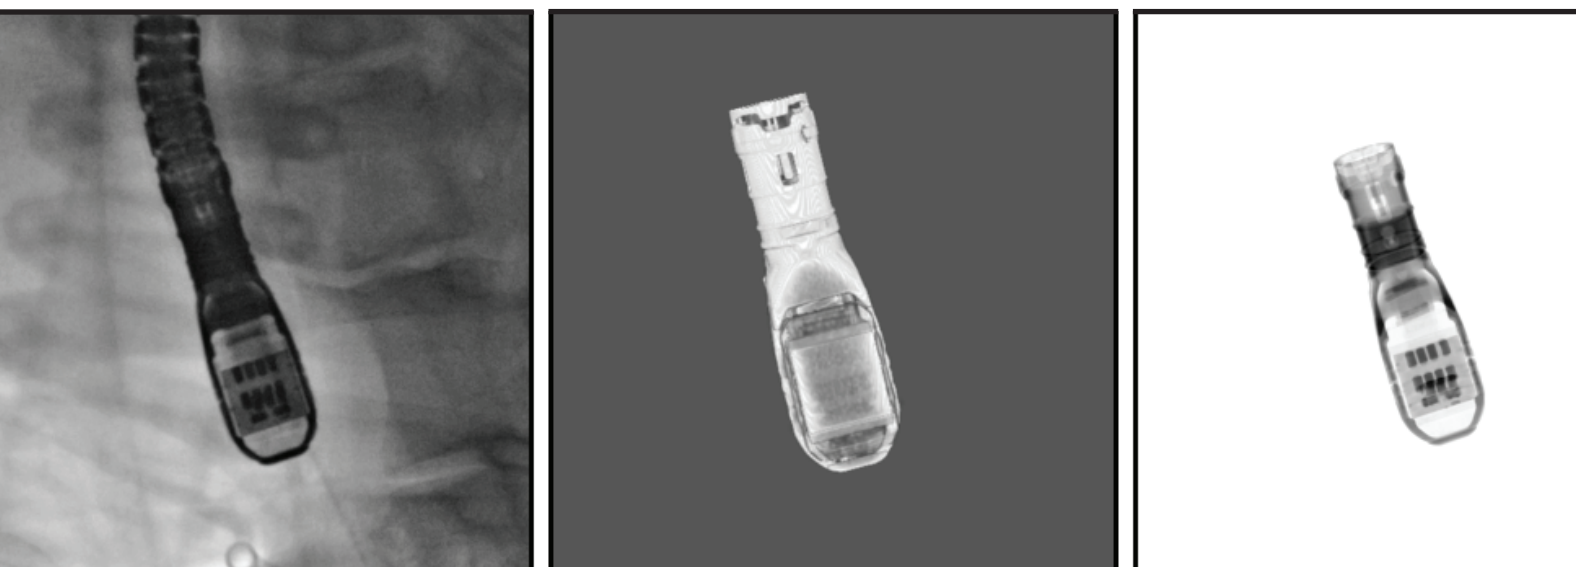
Left: X-ray image containing the TEE probe. Center: Volume rendering of the TEE probe model. Right: Digital reconstructed radiograph (DRR) of the TEE probe model
